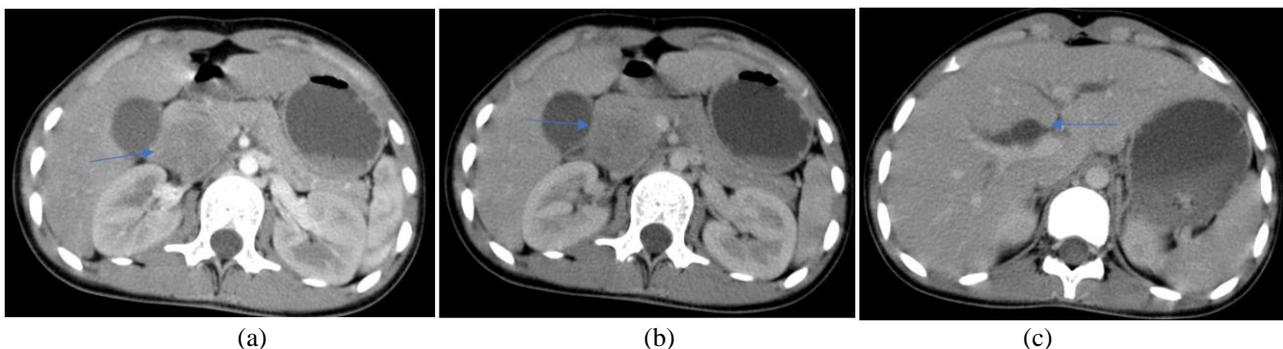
CT scan with axial sections after injection of contrast at arterial(a) and portal (b) phases. The lesion process in the head of the pancreas enhances after injection of contrast medium and is responsible for dilation of the intrahepatic bile ducts (VBIH) and the common bile duct (VBP) (c)
